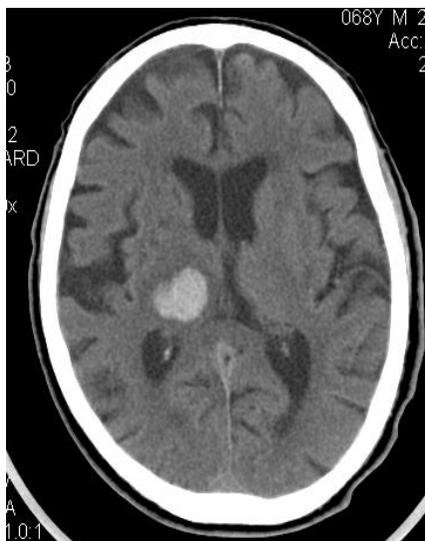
CT Scan of the brain, anonymized patient, Toronto 2010. This image demonstrates a right thalamic intracerebral hemorrhage. The hemorrhage is the rounded white area just to the left of midline.
